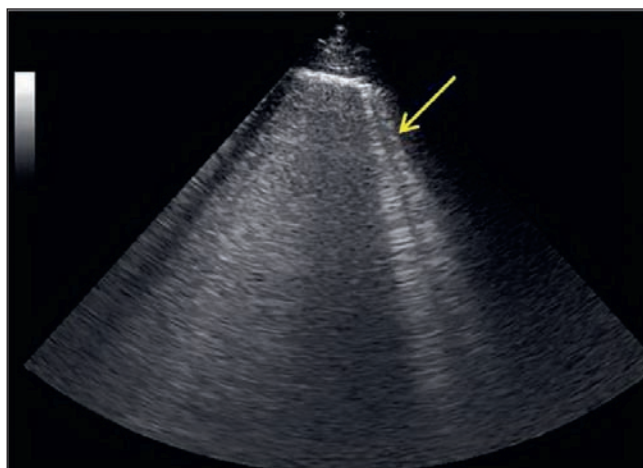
Ultrasound image of the B-line artifact (arrow) (from the personal archive of G.V.Nekludova)
